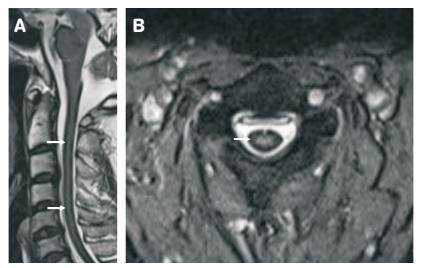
(A), (B): T2-weighted MRI images showing linear hypointensity on surface of cervical cord due to extensive hemosiderin coating (thin arrows).
